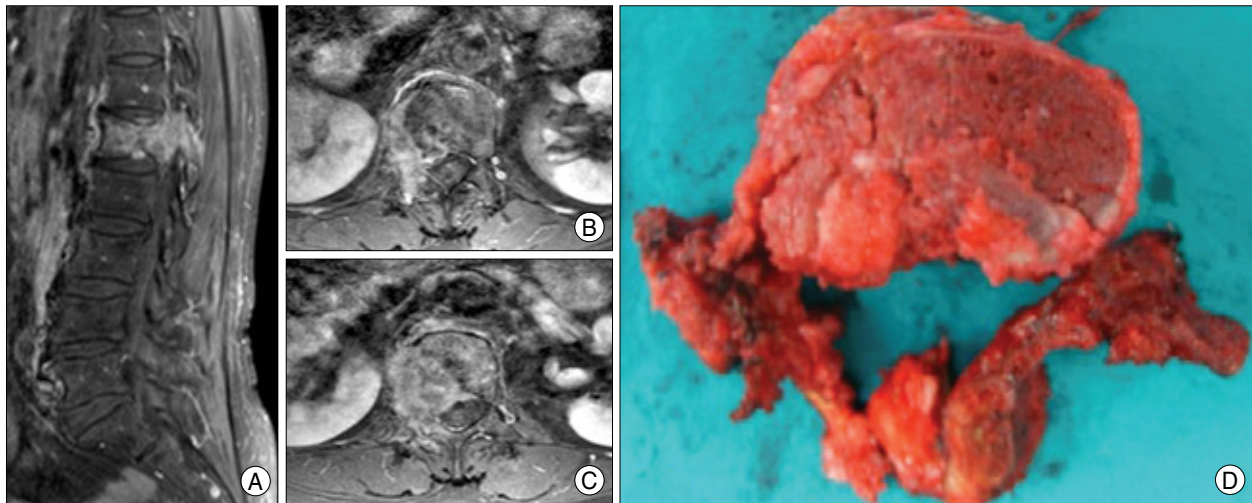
A : Sagittal T1-weighted enhanced magnetic resonance image (MRI), revealing a solitary mass lesion of L1 in which involve the pedicle. B and C : Axial T1-weighted enhanced MRI, showing epidural and paraspinal extension of the mass. D : Totally en bloc resected L1.
